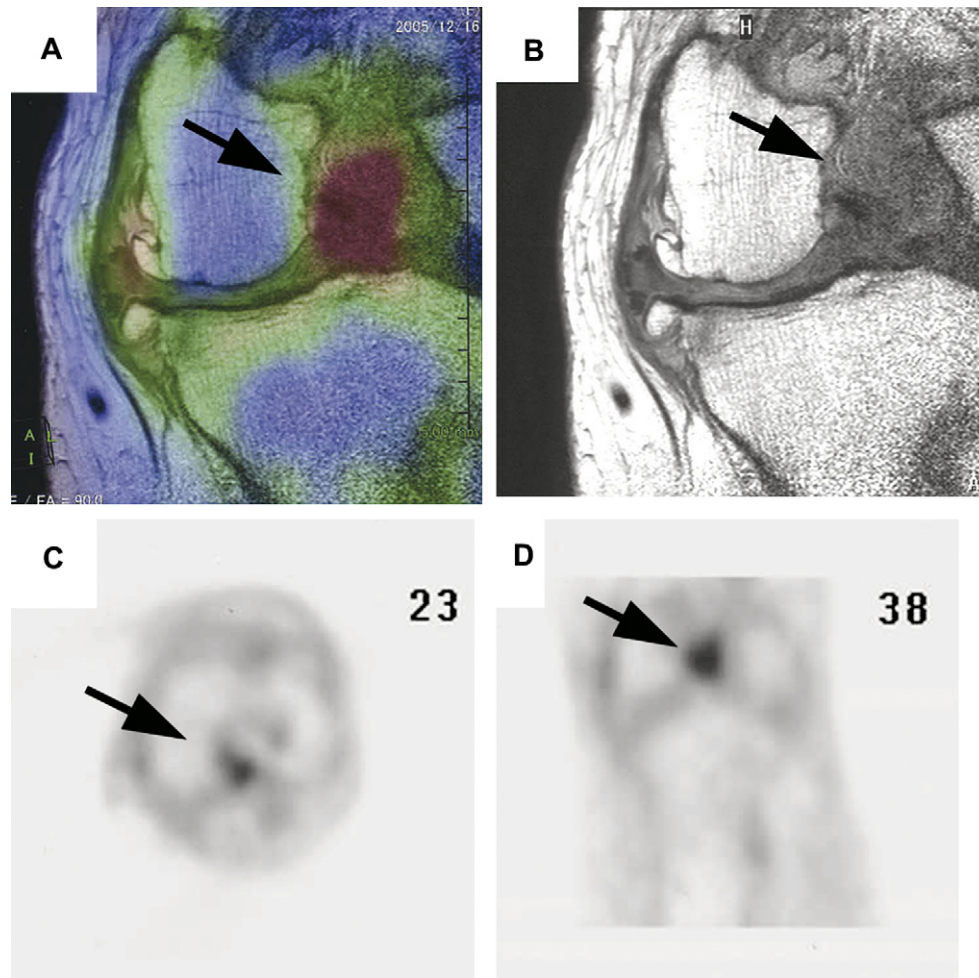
$^{18}\text{F}$ -FDG accumulation extended along PCL (Arrow). (A) Fusion image, (B) MRI, (C) PET axial view, and (D) PET coronal view.
